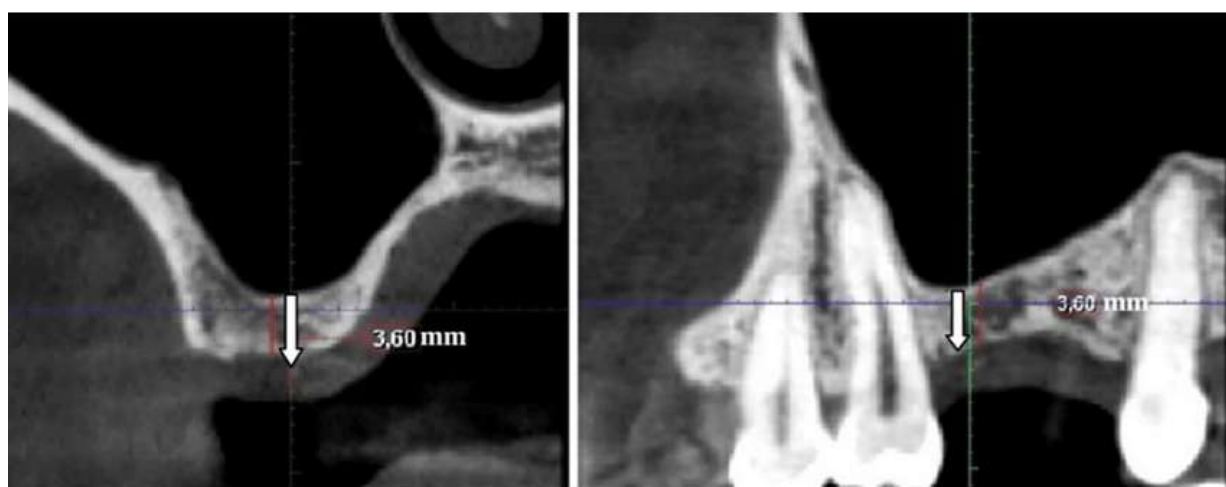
CBCT scan of the right upper first molar region taken preoperatively
